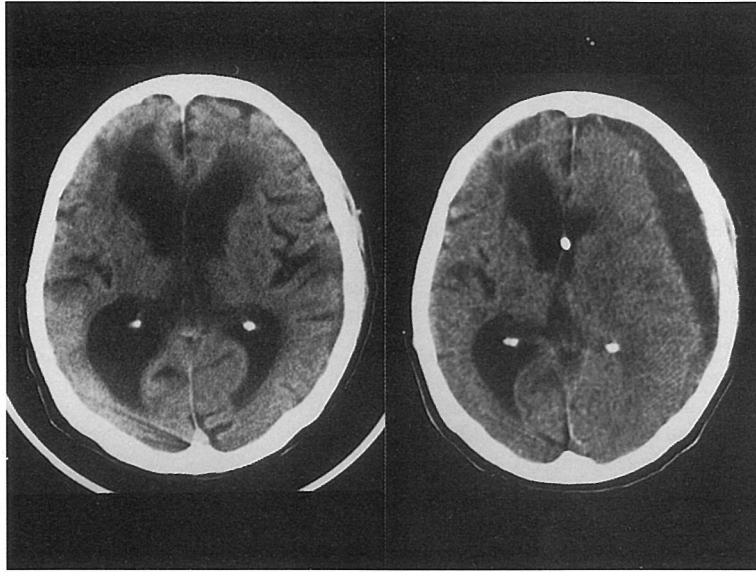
CT scans in case 8. a: Before the shunt operation, hydrocephalus with PVL is present. b: Before the SDH operation, right SDH is present.
